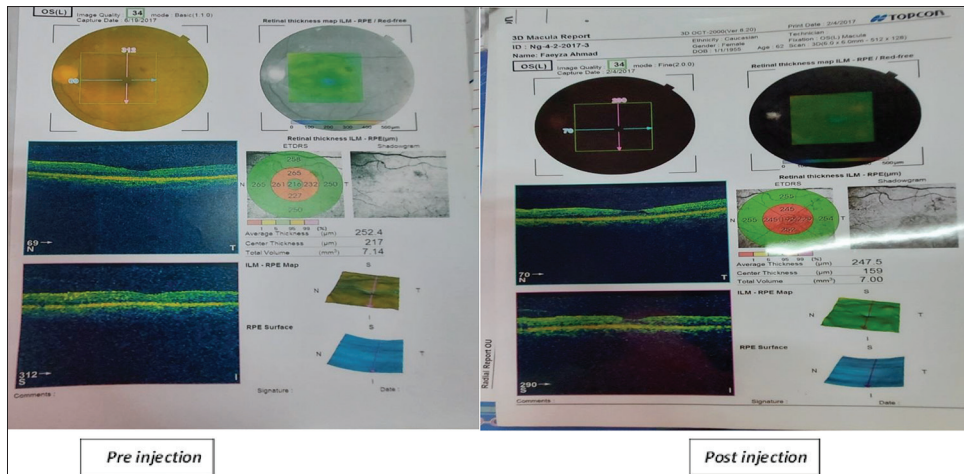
CT of preinjection and postinjection case no. 3. OCT, optical coherence tomography.
